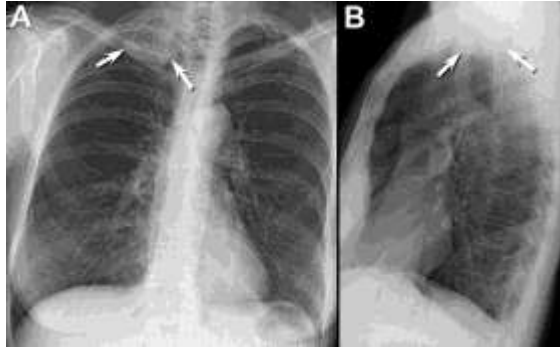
Frontal (A) and lateral (B) chest radiography shows a focal opacity (arrows) without air bronchograms is present in the right apex.
